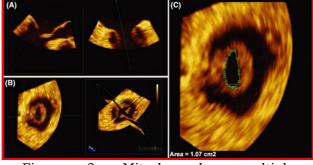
Mitral valve multiplanar trans-esophageal reconstruction by 3D echocardiography. An en face image for the measuring of mitral valve area (MVA) is provided by orthogonal cut planes produced using the narrowest mitral valves orifice at mid-diastole (A) and a perpendicular plane (B). Planimetry of the MVA using the short-axis view following multiplanar reconstruction at the tips of the mitral valve leaflets.
